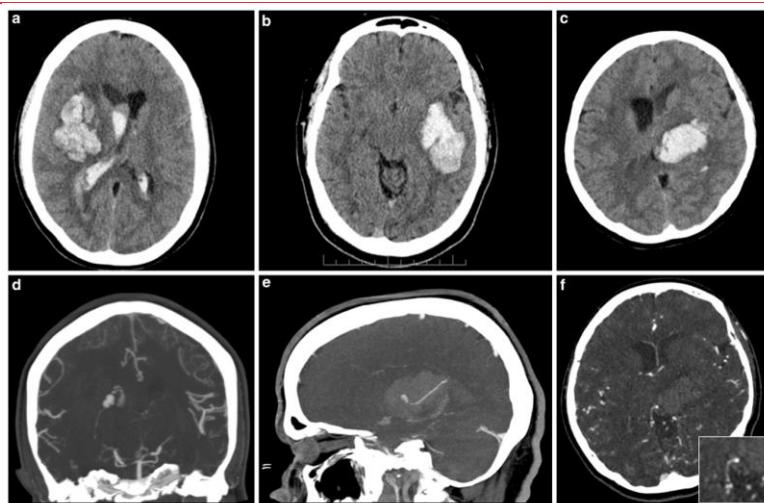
Representative images from three patients: (a, d): patient 1: 30-year-old female, axial non-contrast CT (top row) showing a right frontal parenchymal hematoma with intraventricular extension. Coronal CTA (bottom row) showing a tortuous, dilated lenticulostriatal vessel coursing to the hematoma with a focal aneurysmal portion of the vessel distally, giving a spot on a string (SOAS) sign. (b, e): Patient 2: 42-year-old male, axial non-contrast CT (top row) showing a left temporal parenchymal hematoma, ventricular extension is not shown. Sagittal CTA (bottom row) showing a dilated distal MCA branch coursing into the hematoma with a SOAS sign. (c, f): Patient 5: 54-year-old female, axial non-contrast CT (top row) showing a large parenchymal hematoma centered on the left thalamus. Axial CTA (bottom row) showing a SOAS sign arising from a perforator artery arising from the right posterior cerebral artery.
